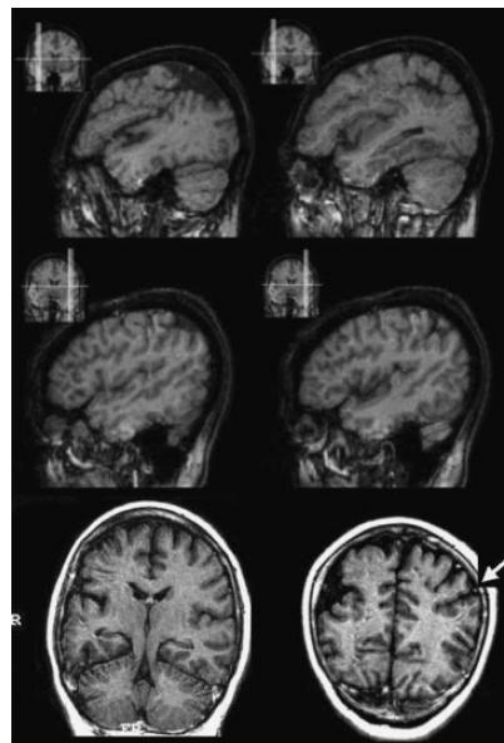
MRI from Patient I-2 (female). T1-weighted sagittal and coronal images show asymmetrical bilateral perisylvian polymicrogyria more pronounced in right hemisphere (top row). The mild polymicrogyria on the left hemisphere is present in the posterior extension of the Sylvian fissure which is better appreciated in the coronal images (arrow).
